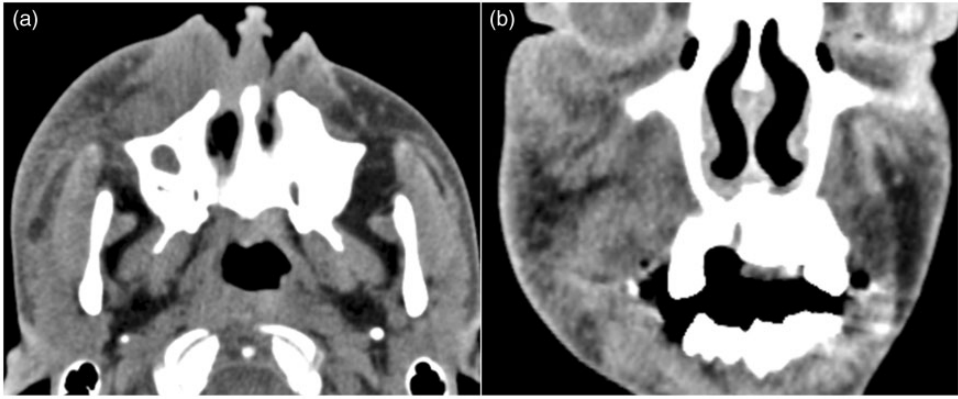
A 16-year-old male patient presented with a 1-month history of right facial edema. (a, b) Computed tomography images of the mass beneath the skin.
